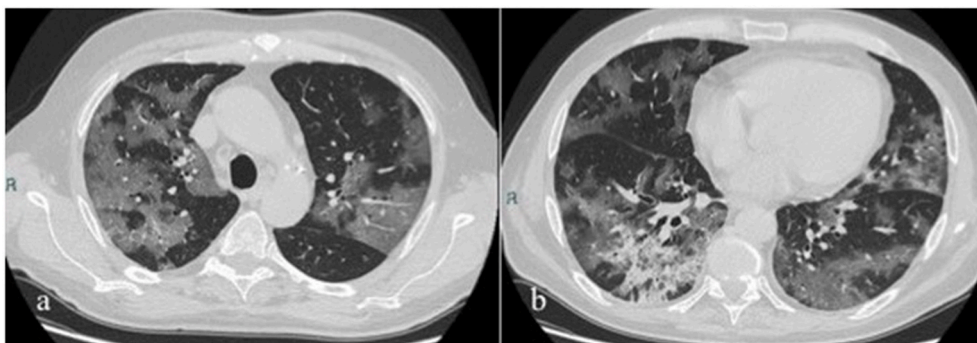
a–b. HRCT chest images of patient with COVID-19 ARDS. The HRCT chest images shown multifocal, bilateral ground-glass opacity, interlobular septal thickening and bilateral infiltrates, involving 50–75% of the lung parenchyma, without adenopathy and pleural effusion.
